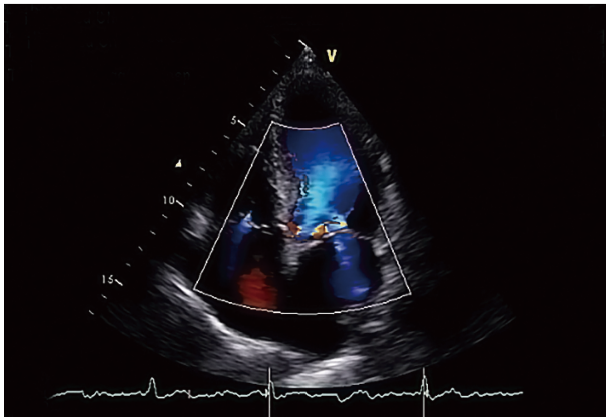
Outpatient ultrasonic cardiogram. Ultrasonic cardiogram shows enlarged left and right atrium under atrial fibrillation rhythm, and moderate amount mitral regurgitation, with no evidence of structural valvular heart disease.
